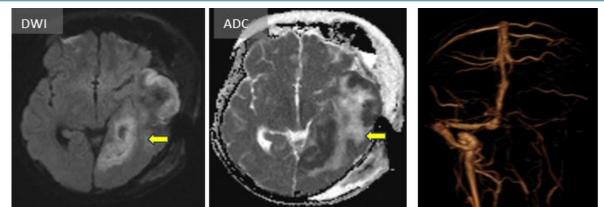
CT brain shows, ill-defined hypodensity in left temporal and medial occipital lobe (*yellow arrows*) with hyperdense areas within and mass effect causing significant midline shift. MR venogram post decompression craniectomy shows, a large area of signal abnormality involving left temporal lobe (*red arrows*) which is hyperintense on FLAIR with restriction on DWI and with evidence of extensive blood products on SWI. No flow related signal in left transverse and sigmoid sinuses.
